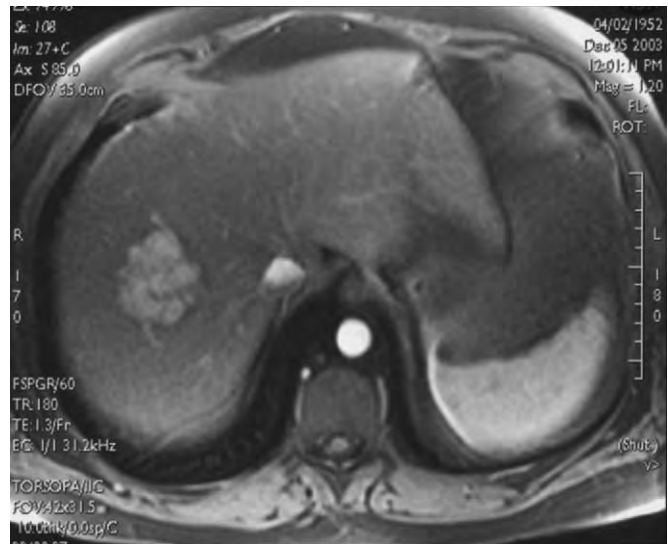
Dynamic contrast-enhanced MRI of focal nodular hyperplasia presenting as a hypervascular lesion with a central scar.
